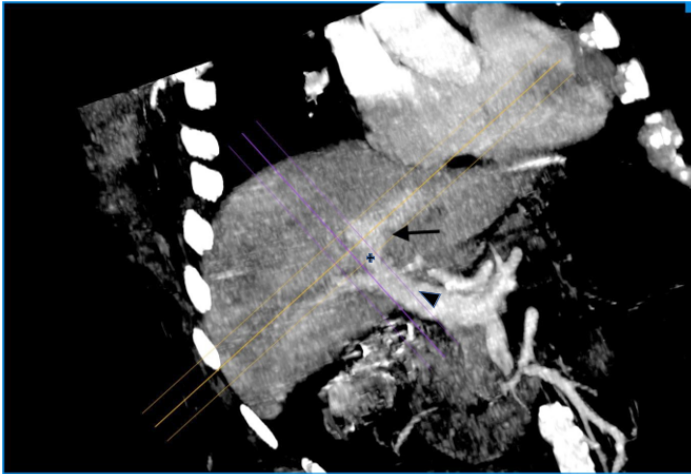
CT scan, MIP reconstruction from the portal venous phase scan showing the intrahepatic porto-systemic shunt (arrow), portal vein (arrowhead) and hepatic vein (plus).
